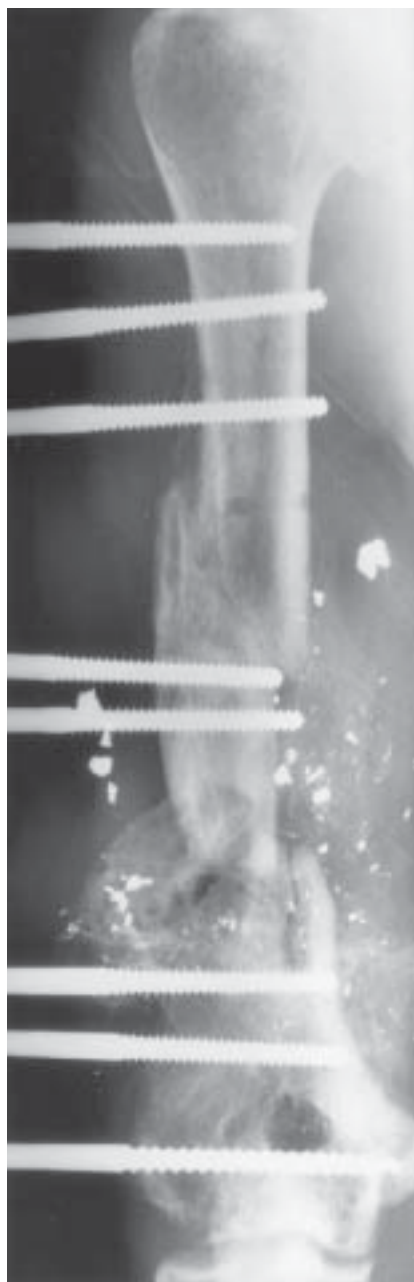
An AP radiograph taken six months after injury demonstrating repair at both levels. No bone grafts were used.
